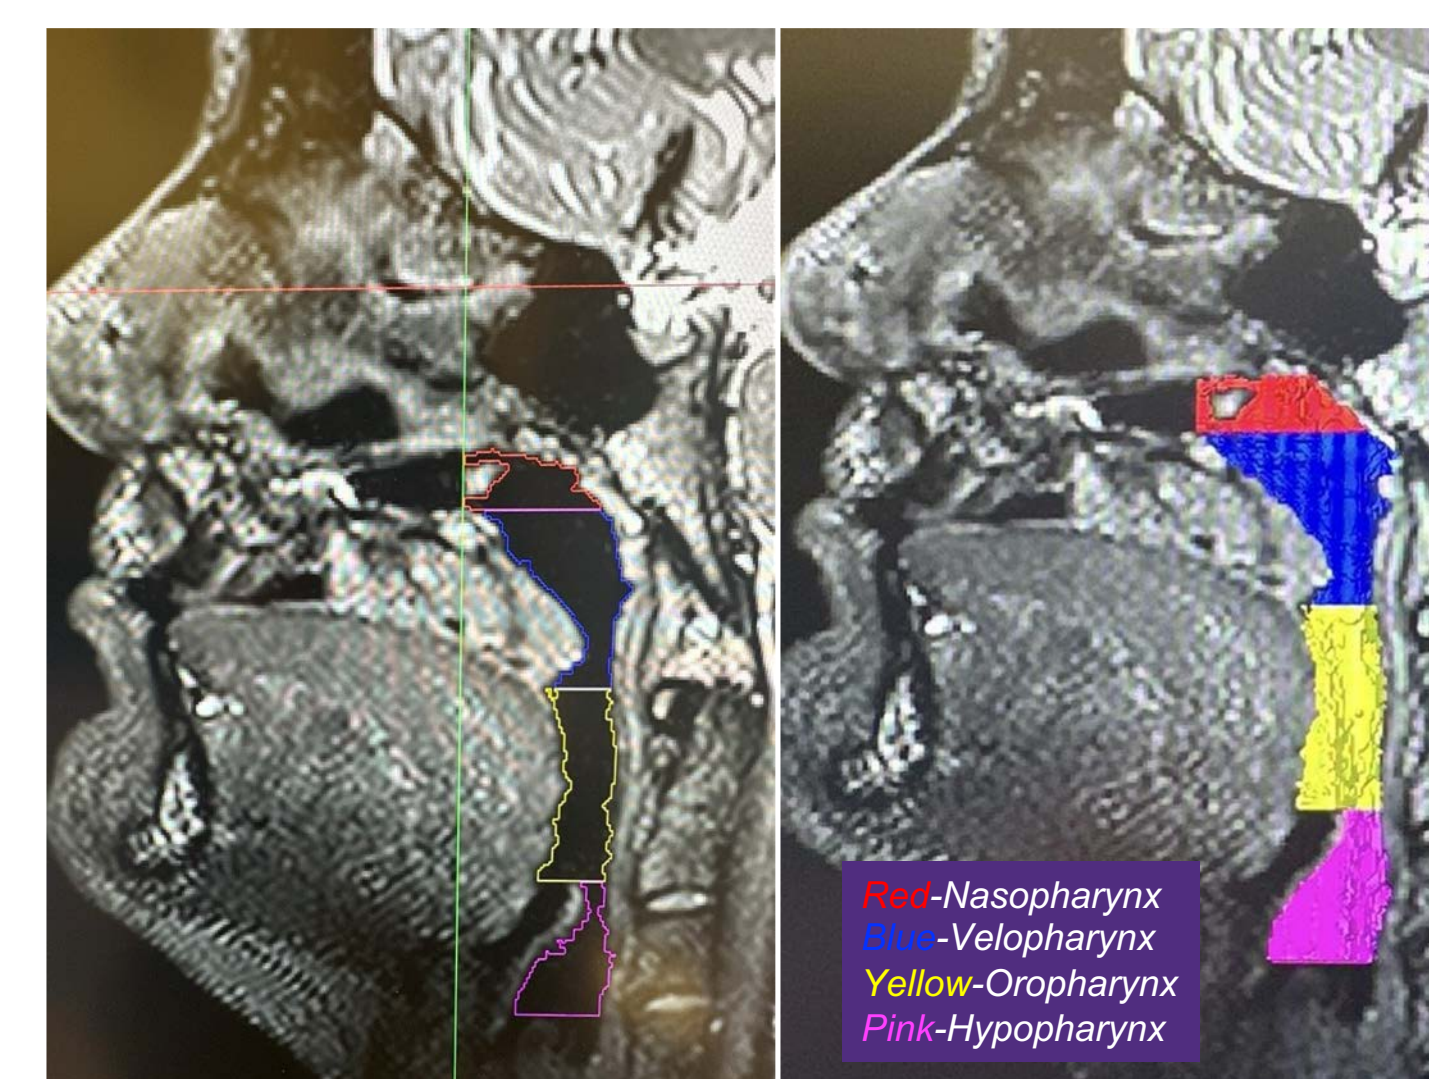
Segmentation procedure implemented in the current study. The figure depicts the 4 separate airway divisions. Borders were adapted from Ogawa's (2015) MRI study.
